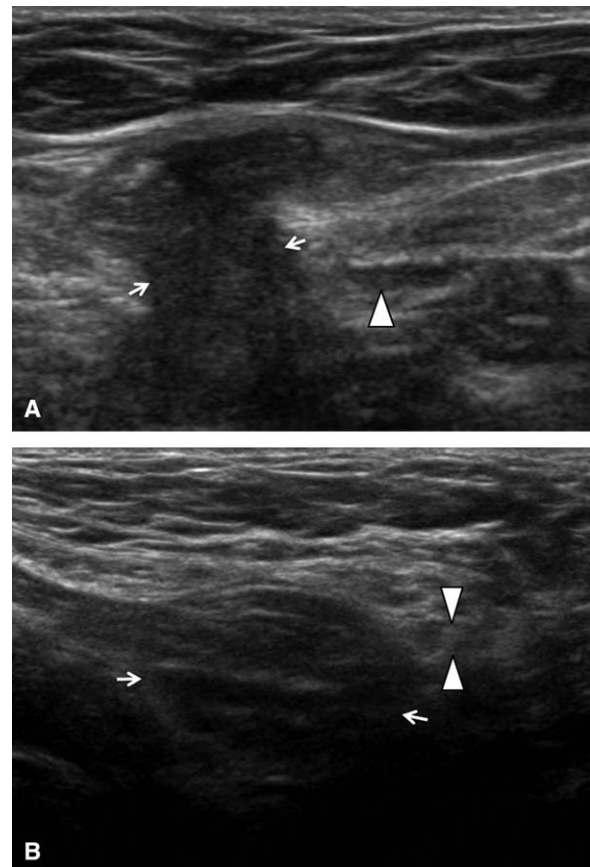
(A) Transverse sonogram of a left groin shows a direct inguinal hernia. The neck (arrows) of the hernia is arising medial to the inferior epigastric artery (arrowhead). (B) Longitudinal sonogram from the same patient shows the neck (arrows) of the direct inguinal hernia arising superior to the inguinal ligament (arrowheads).
